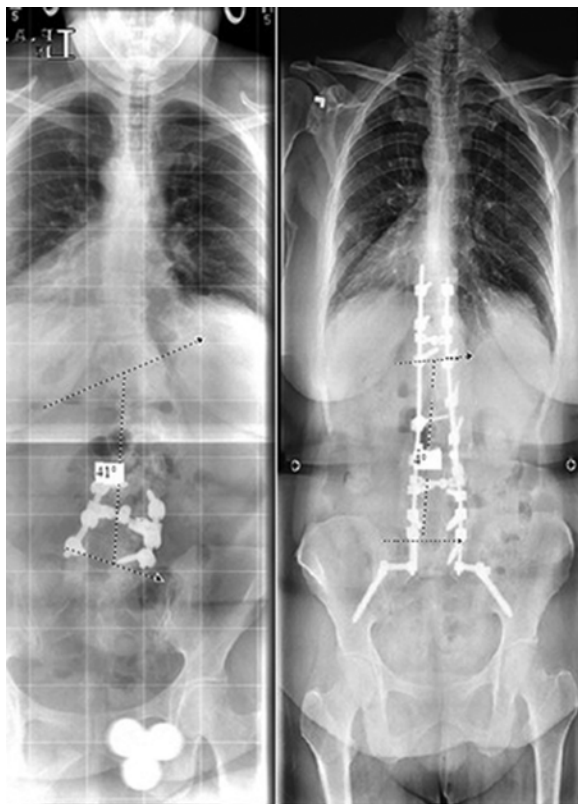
Preoperative (left) and postoperative (right) standing PA long-cassette scoliosis series radiographs in a patient who underwent a combined approach with minimally invasive transpsoas XLIF and revision open posterior segmental pedicle screw instrumentation for correction of adult degenerative scoliosis. Interbody grafts were placed via a transpsoas approach from L-1 to L-4. The patient had 90% correction of her coronal Cobb angle.
